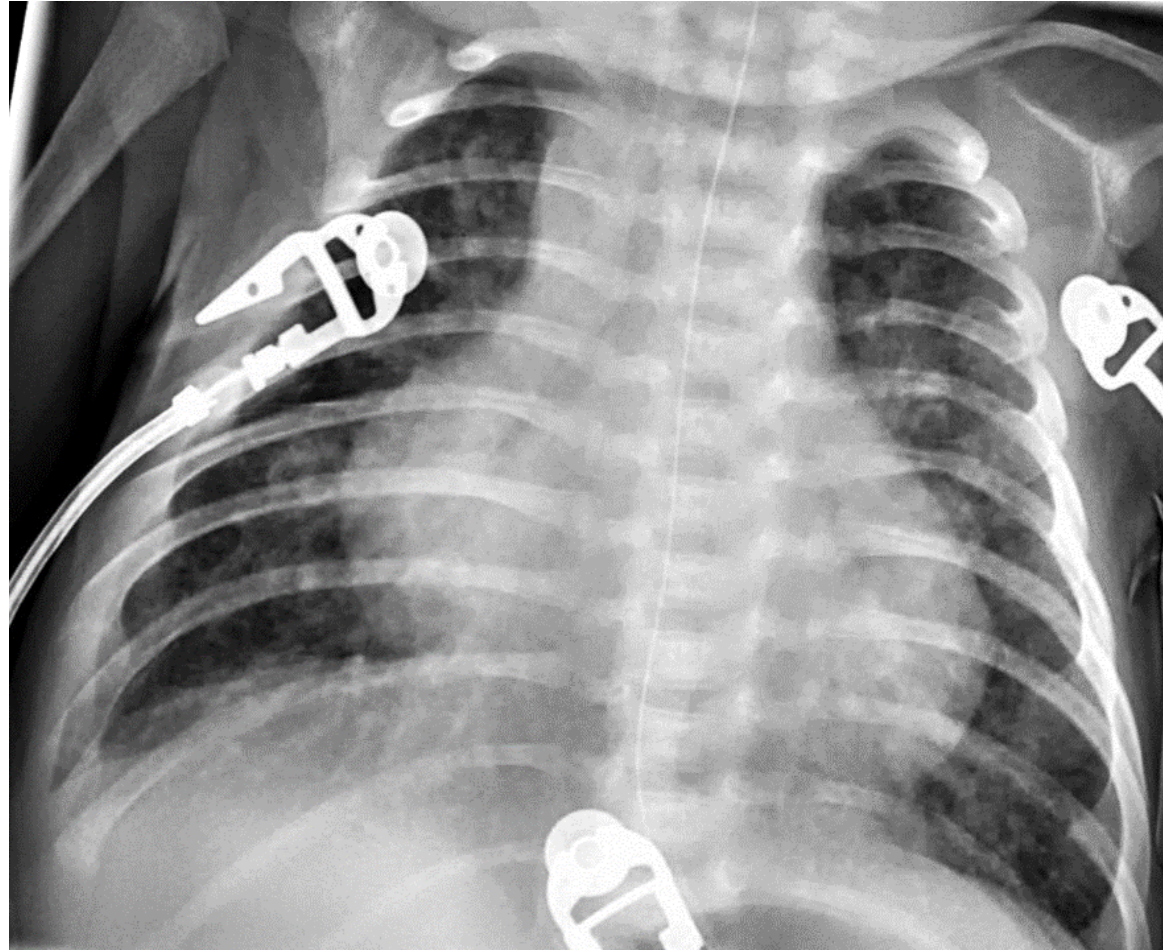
CHEST RADIOGRAPH OF A PATIENT SHOWING FEATURES OF CONGESTIVE HEART FAILURE
